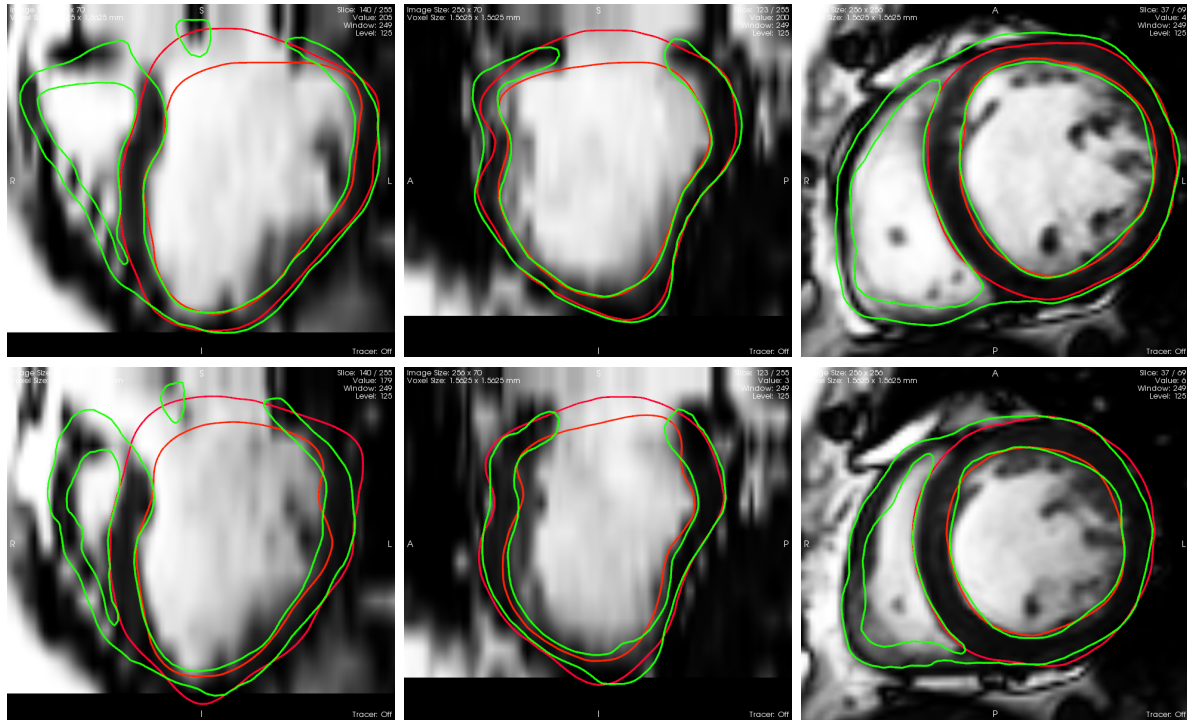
Results of the motion tracking: manual delineation of LV blood pool and LV epicardium (without valves, red line) estimated myocardial mesh (green line) superimposed with cine-MRI at (top) end-diastole and (bottom) end-systole.
